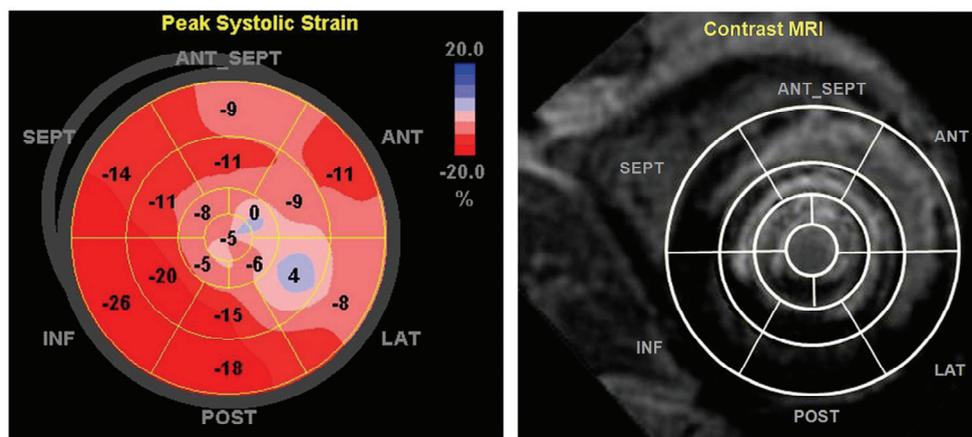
Bulls eye plot of peak systolic longitudinal strain by speckle tracking echocardiography (left) and gadolinium contrast MRI (right). The center of the plot represents apex, and the rim represents the basal LV segments
